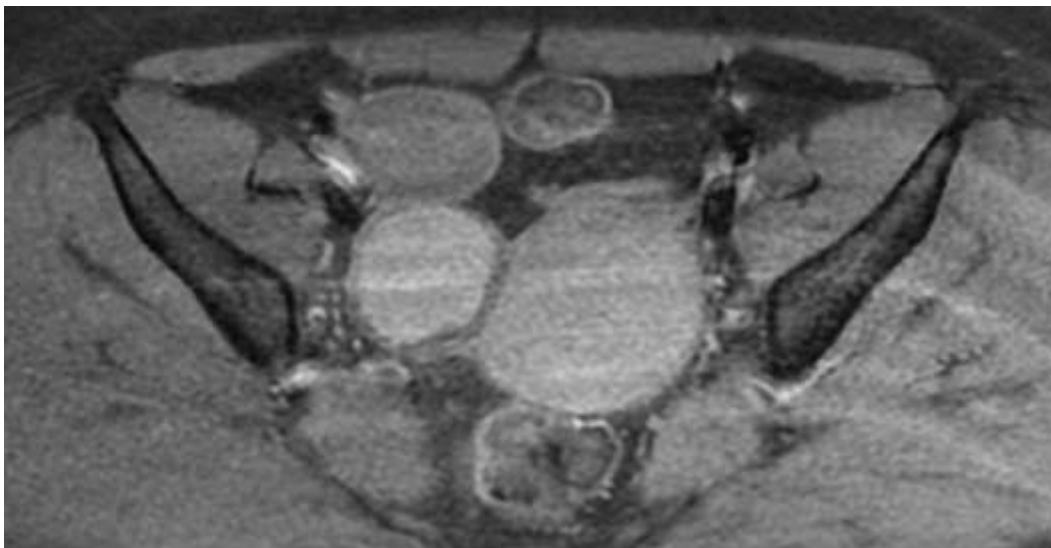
FAT-Saturated post gadolinium T1 (MRI): 2 lateral-uterine formations in hypersignal
